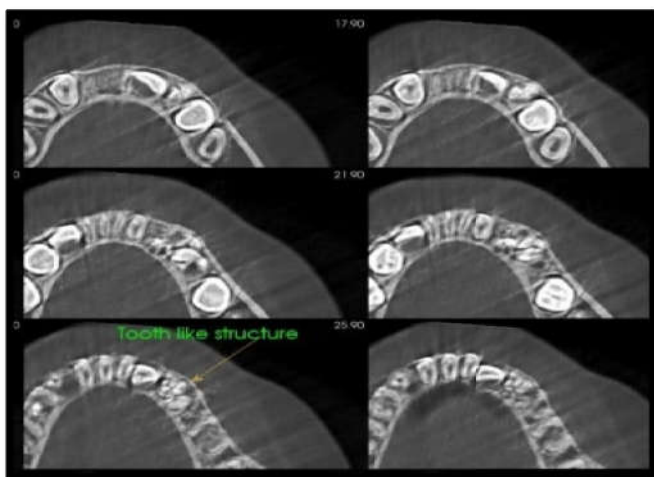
CBCT (volumetric and axial views) depicting the odontome and associated retained permanent teeth
